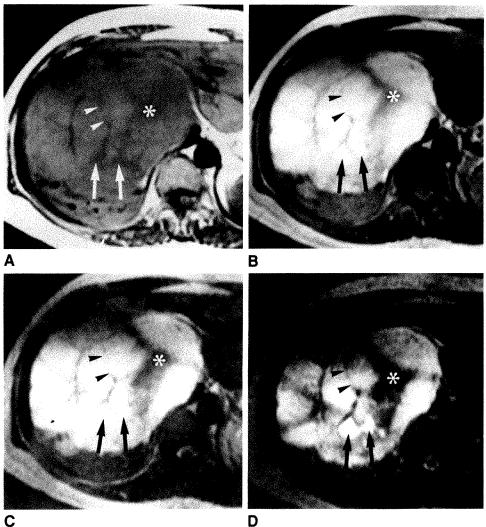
Giant cavernous hemangioma of liver in 43-year-old woman with epigastric discomfort. Axial MR images (A-D) are on this page; postcontrast CT findings (E-H) are on facing page.
